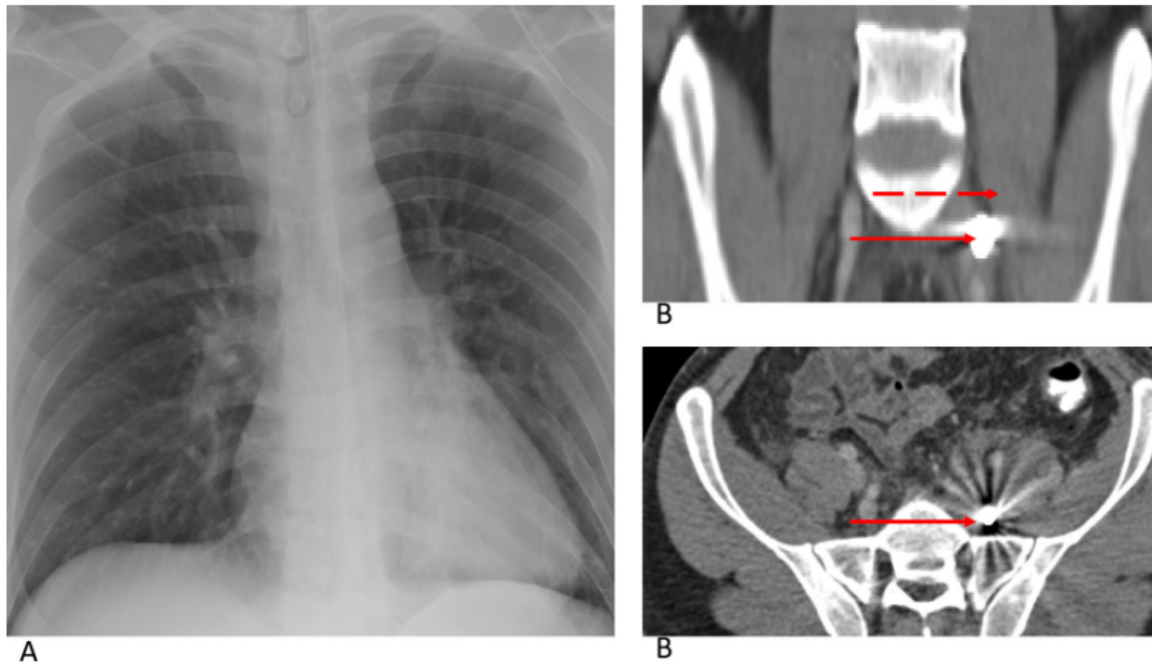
(A) Chest X ray showing no abnormalities. (B) Abdominal CT showing a bullet (red arrow) medial to the iliopsoas muscle (red dashed arrow).
